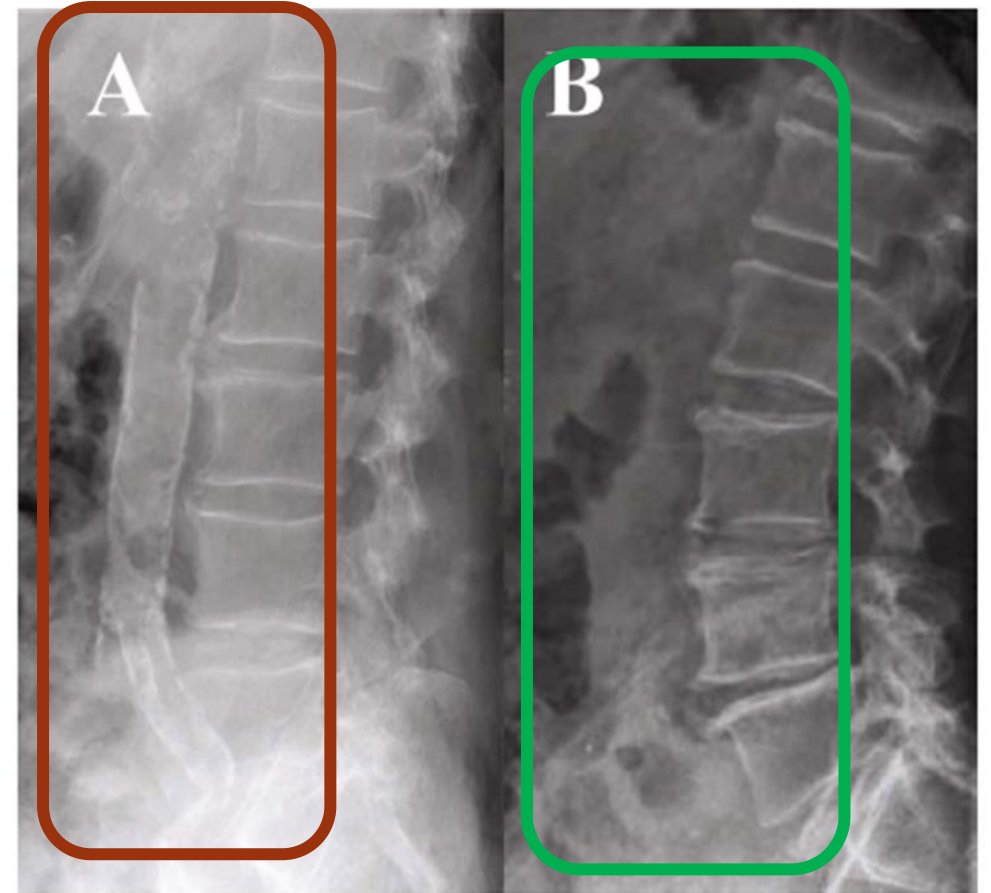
Plain X-ray of (A) a 59-year-old patient with abundant abdominal aortic calcification (AAC = 21) and (B) a 73-year-old patient with no calcific deposits in the abdominal aorta (AAC = 0).
